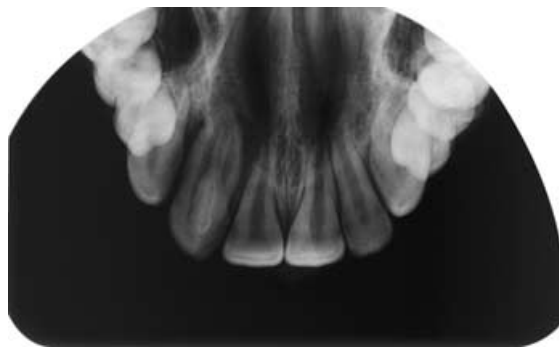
Occlusal radiograph showing the dens invaginatus malformation of the upper right lateral incisor; the left lateral incisor has no signs of pathology or malformation.
